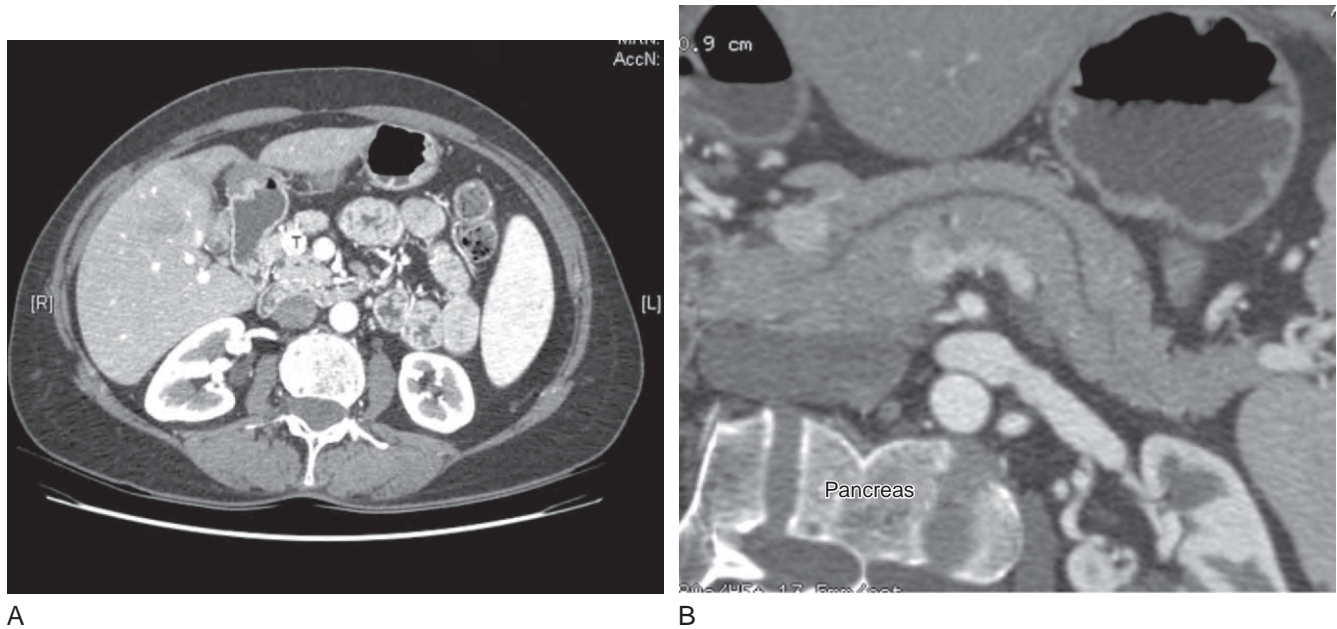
A, CT of a small insulinoma (T) within the head of the pancreas. B, Three-dimensional reconstruction of the same CT, which shows the small hypervascular insulinoma within the head of the pancreas.
